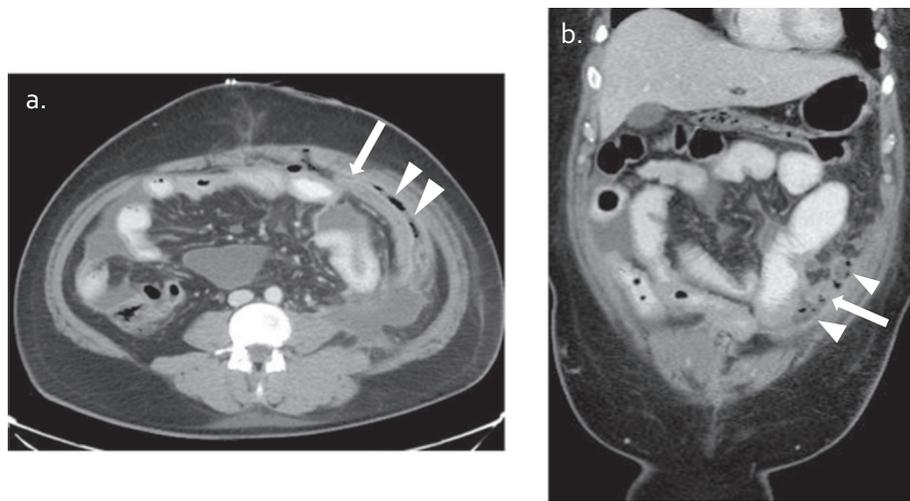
Stomal retraction: axial (a) and coronal (b) CT images in 29 year old male who presented with large bowel obstruction due to diverticulitis and underwent Hartmann procedure. CT demonstrates retraction of the colostomy into the peritoneal cavity (distal end of colostomy - arrow) with foci of free air (arrowheads).
